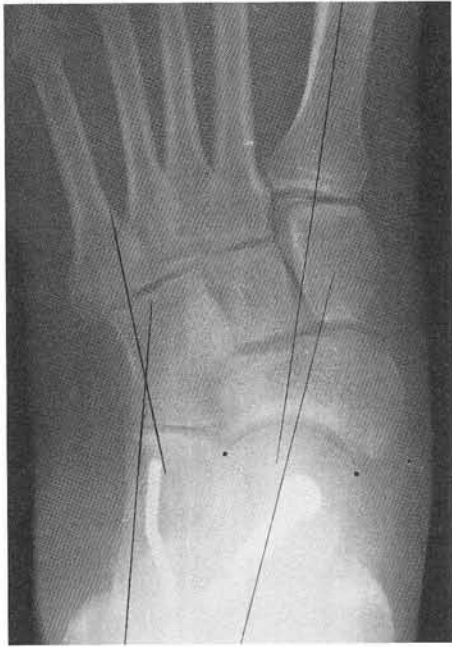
Long-term follow-up weight-bearing radiograph. The patient is now 2 years postoperative and has had an excellent clinical outcome and result.
